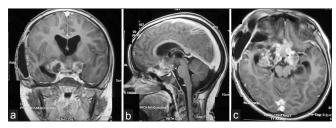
(a-c) Postoperative magnetic resonance imaging (coronal, sagittal and axial) after 3rd surgery showing reduction in tumor volume
